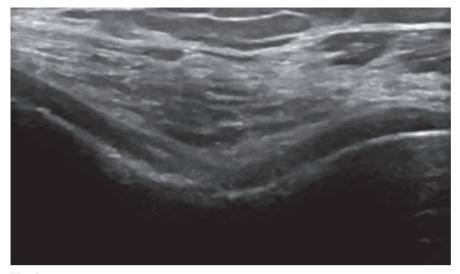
Ultrasound of the femoral hyaline cartilage in knee in OA, showing irregularities of cartilage margins, inhomogeneity of the echotexture with loss of the anechoic structure, and thinning of the cartilage layer.
